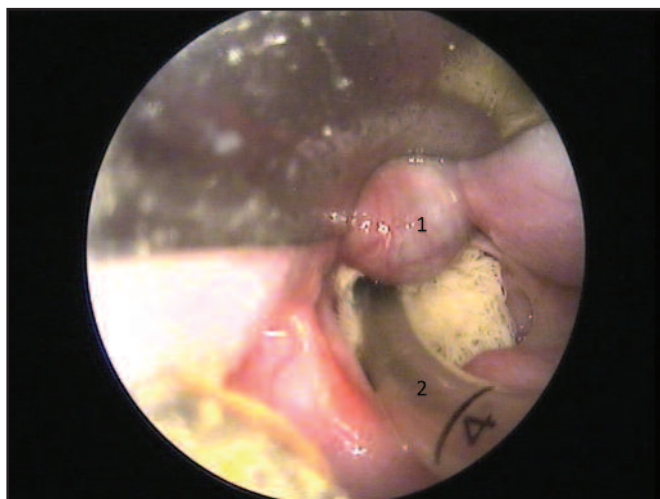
Intraoperative photograph of 2 month old male baby with vallecular cyst (Label- 1). Label -2- endotracheal intubation. CT PHOTOGRAPH: CT (Base skull to thoracic inlet) showed a well-defined clear enhancing mid-line thin wall cystic lesion of 16x15mm at the base tongue (Black Arrow) (White Arrow- Epiglottis).
